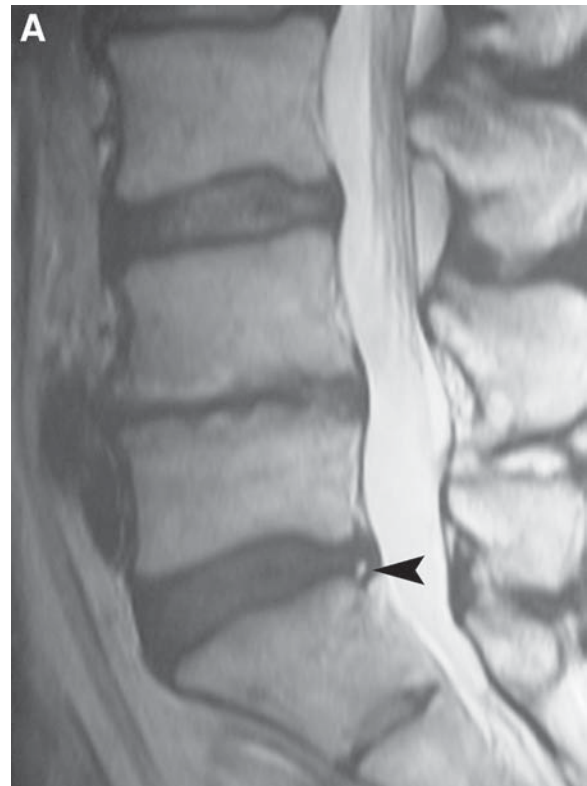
Enhancing HIZ. (A) Sagittal T2 image shows a small focus of hyperintensity (*arrowhead*) within the posterior annulus fibrosis. (B) Intravenous contrast enhanced sagittal T1 image shows enhancement within the posterior annulus fibrosis (*arrowhead*) corresponding to the HIZ identified on the T2-weighted image. This phenomenon is thought to reflect the ingrowth of fibrovascular tissue to the area.
